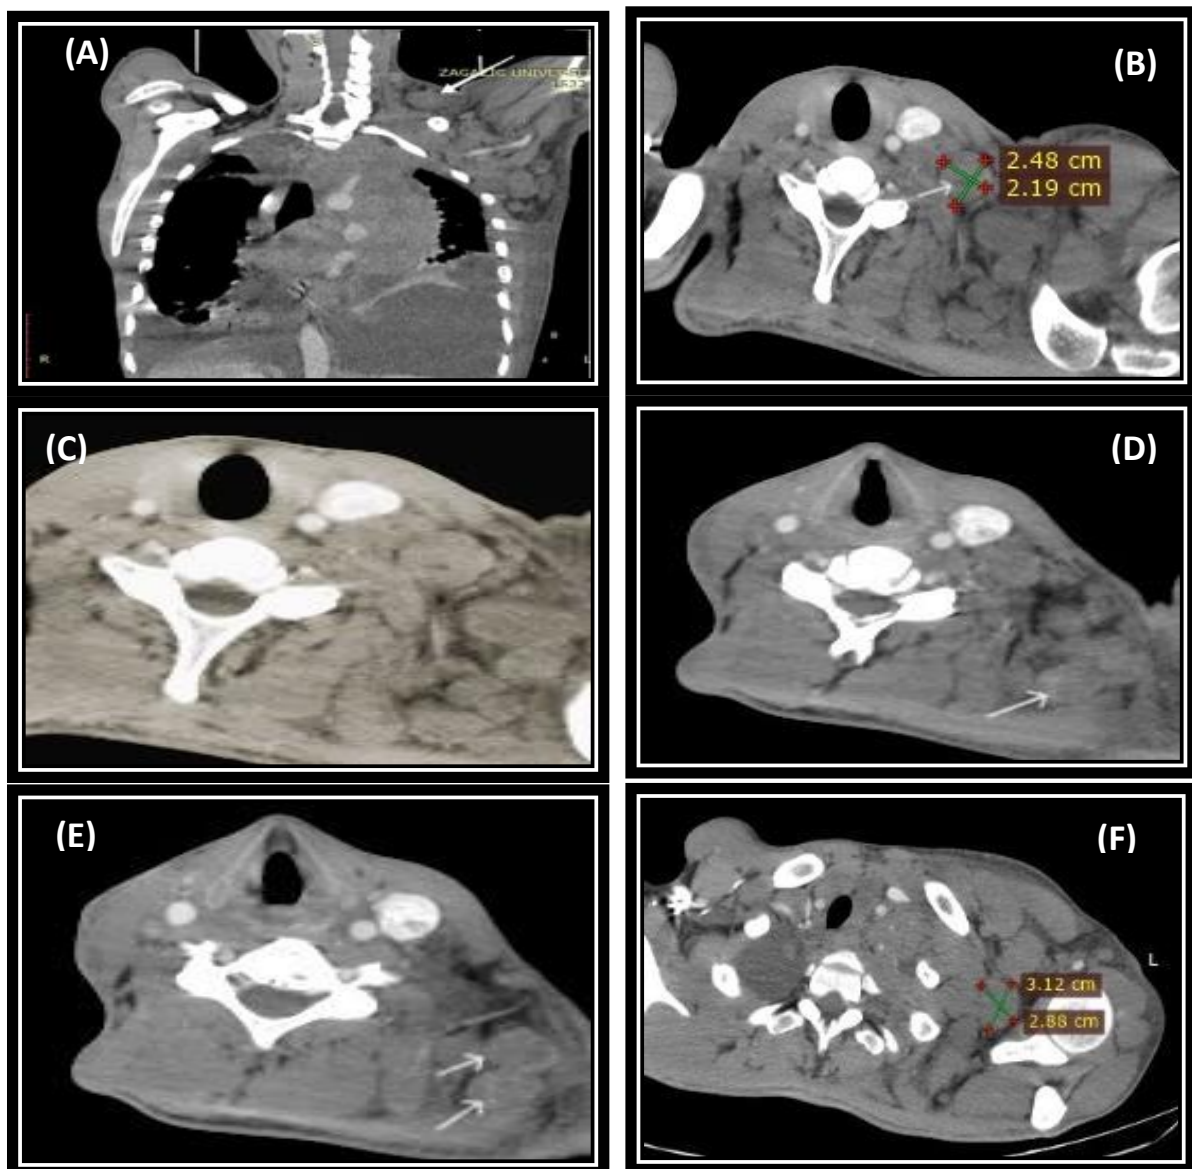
55 years old male patient present with painless neck swelling, MDCT axial and coronal views with IV contrast (A): MDCT coronal view shows LT enlarged Medial supraclavicular lymph node (level IVb), also bilateral pleural effusion noted, (B): axial CT cut revealed enlarged left medial supraclavicular LN with its measurement, (C): Lymph nodes show
